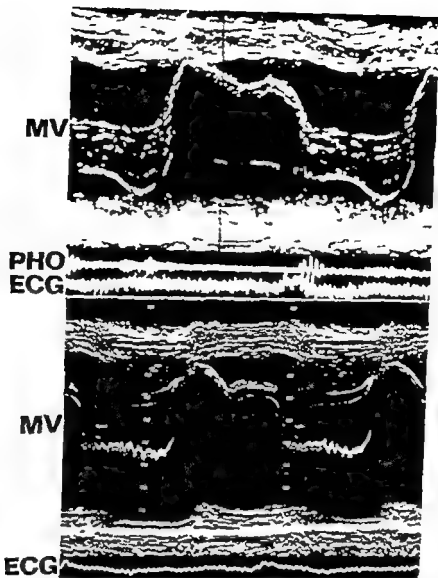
Upper panel* Mitral valve echocardiogram prior to bacterial endocarditis (Case 1) Note the typical prolapse pattern and absence of systolic flutter *Lower panel* Mitral valve echocardiogram following bacterial endocarditis Note the development of high frequency systolic flutter Other records obtained with higher gain settings demonstrated shaggy thickening and diastolic instability highly suggestive of bacterial endocarditis with chordae rupture
